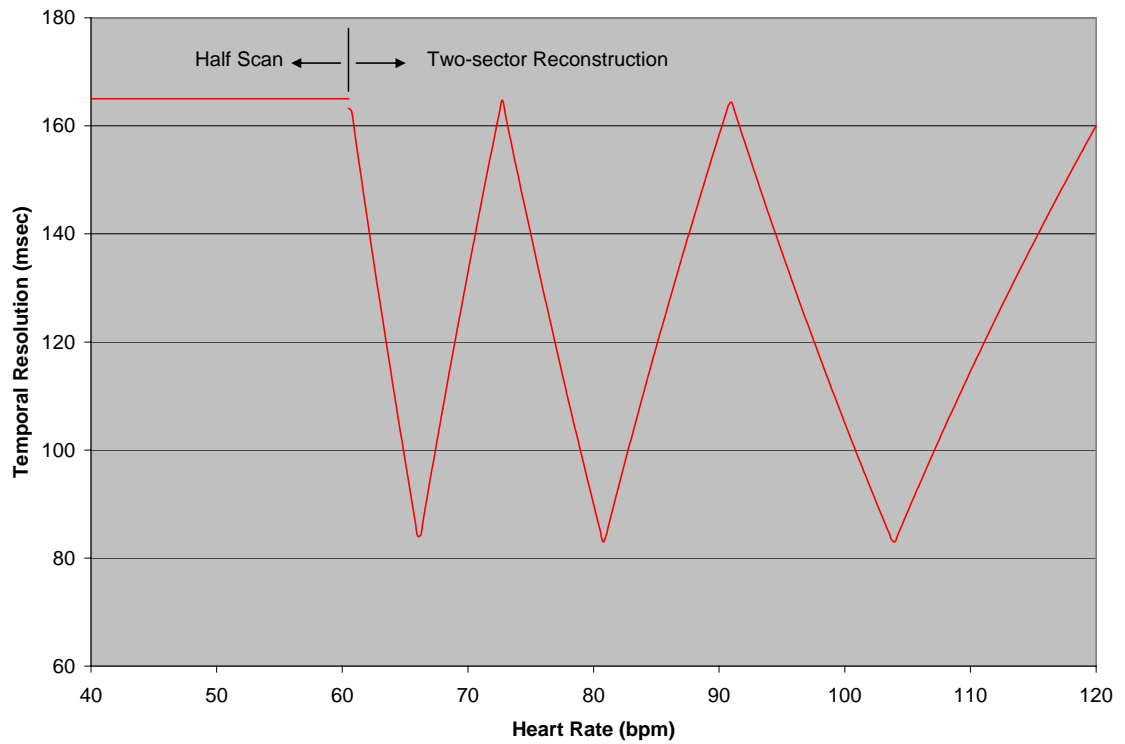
CT temporal resolution as function of heart rate for 330msec rotation
